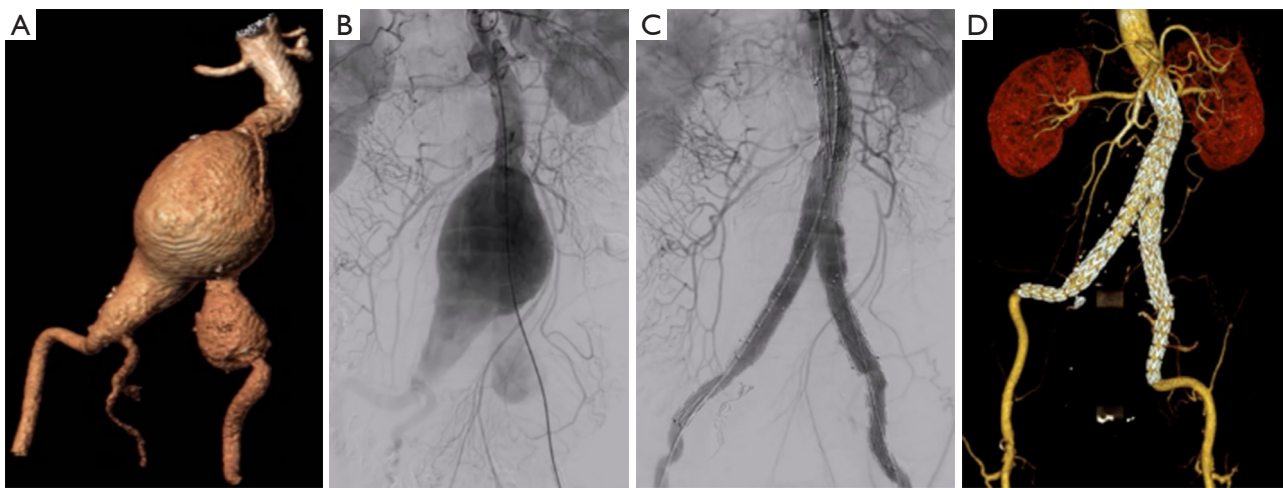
Perioperative CTA and DSA images of the first EVAR operation. In December 2020, preoperative CTA (A) and intraoperative DSA (B,C) images of the patient at the first surgery. CTA follow-up one month after the operation showed that the aneurysm was well isolated without endoleak or iliac branch occlusion (D). CTA, computed tomography angiography; DSA, digital subtraction angiography; EVAR, endovascular repair of abdominal aortic aneurysm.
